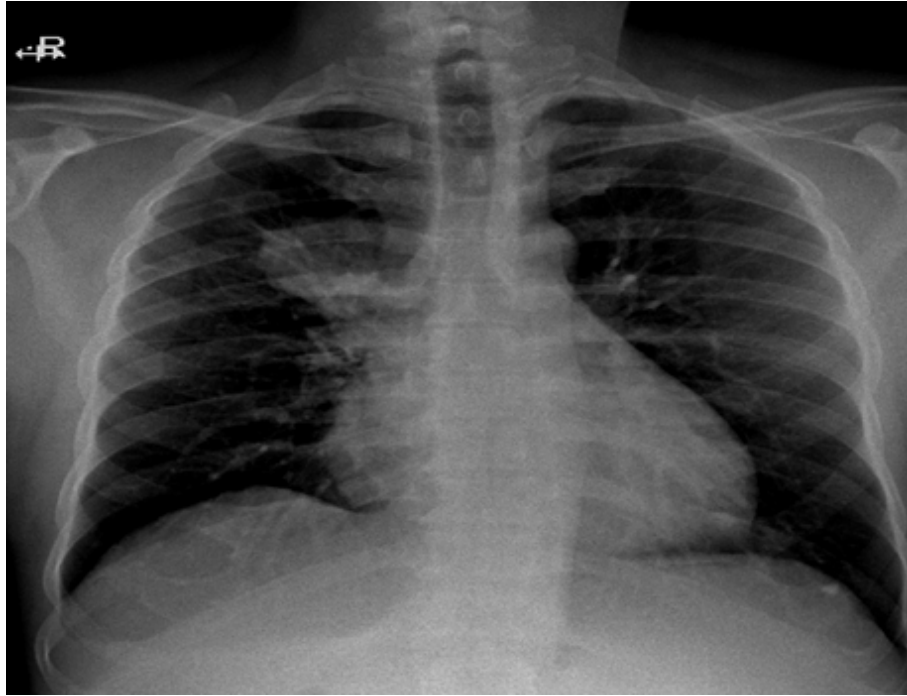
Initial chest X-ray. The X-ray shows right para tracheal opacity.
